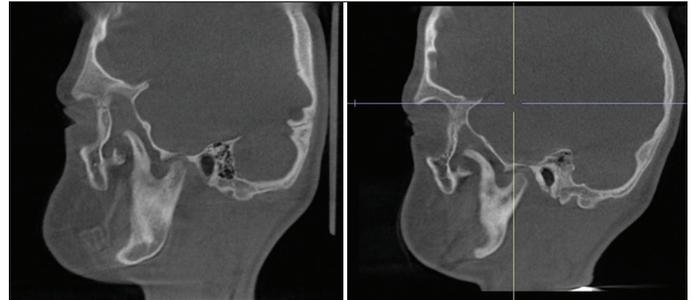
Left and right sagittal computed tomography scans for the first patient showing coronoid hyperplasia
